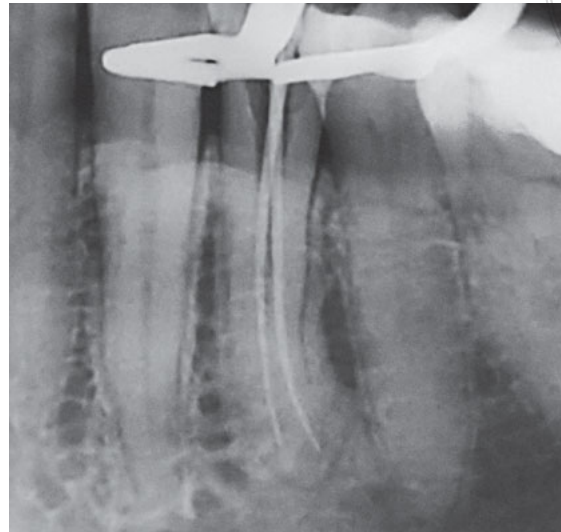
Gutta-percha master cones radiograph.
